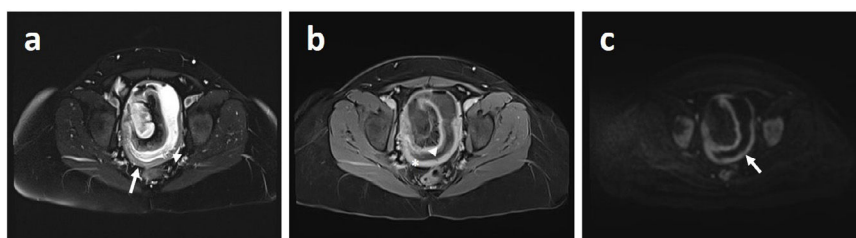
Axial plane MRE images of an inflammatory ileitis in a subject with CD. a) T2-weighted sequence with fat suppression allowing detection of mural oedema (*arrow*) and ulcers (*arrowhead*). b) T1-weighted sequence with IVC to identify the mural enhancement/thickening (*asterisk*). This sequence also allows the detection of ulcers (*arrowhead*). c) Diffusion-weighted sequence, optional, but very sensitive for ruling out inflammation and collections. Restriction of diffusion is seen in the wall of the inflamed ileal loop (*arrow*).
